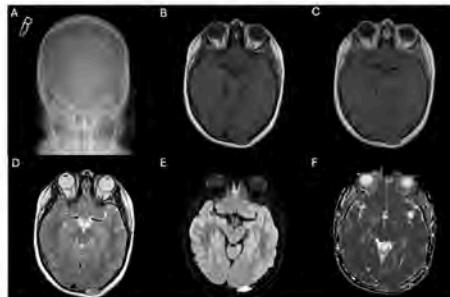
11-year-old boy with swelling in the left occiput. A. Skull radiograph Towne projection demonstrates a circumscribed lytic lesion in the left occipital bone. B. Axial T1 pre-contrast sequence shows an expansile intermediate signal intensity mass in the left occipital calvarium. C. No associated enhancement of this mass is seen on T1 post-contrast sequence. D. Axial T2 sequence shows heterogeneous intermediate to high signal within this mass. E. DWI sequence demonstrates restricted diffusion associated with this mass, confirmed on F. ADC map.
